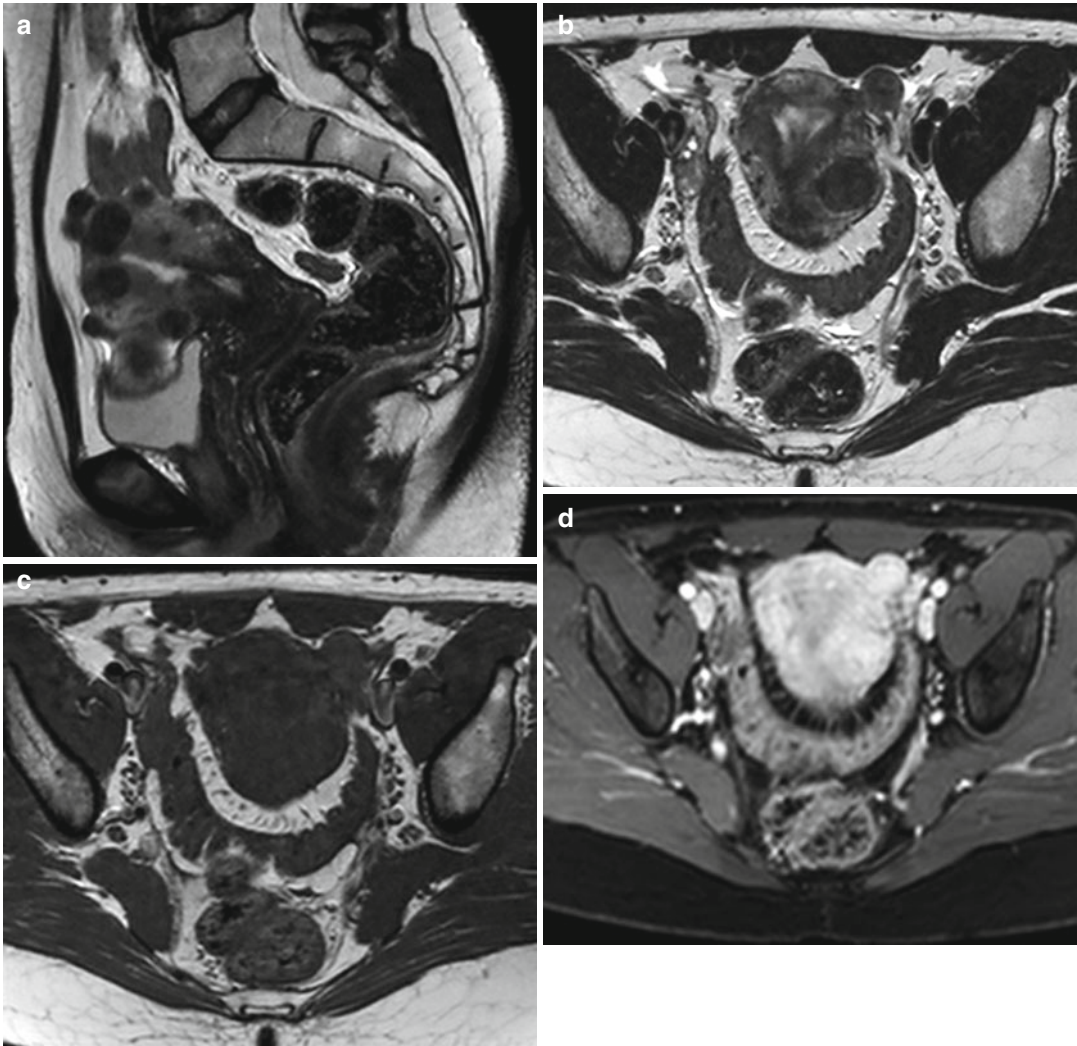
Multiple uterine leiomyomas. Uterine leiomyomas are well-defined masses in the myometrium, with a homogeneous low signal intensity on T2-weighted images (TR 4,000 ms, TE 100 ms) (a, b) and a homogeneous isointense signal on T1-weighted image (TR 590 ms, TE
